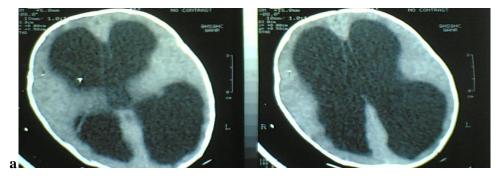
a,b: CT brain images in successful ETV case; a) Pre op, b) Post op 3 months showing lax sulci and disappeared transependymal permeation.
